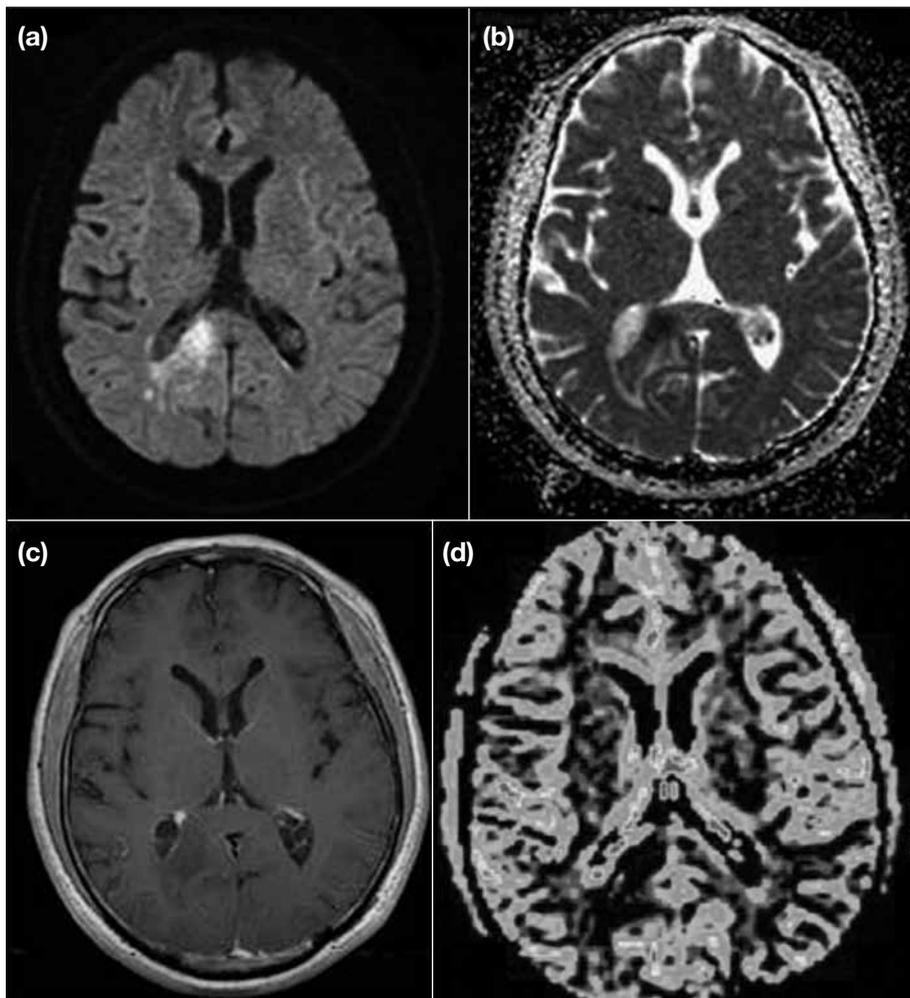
Magnetic resonance images on admission showing cerebritis. (a) A diffusion-weighted image shows hyperintense signal in the splenium of the corpus callosum, (b) apparent diffusion-coefficient map shows corresponding hypointense signal intensity, (c) postcontrast T1-weighted image shows no contrast enhancement around a hypointense area, and (d) relative cerebral blood volume map shows no evidence of increased vascularity in the splenium of the corpus callosum, which is suggestive of a non-neoplastic lesion.
